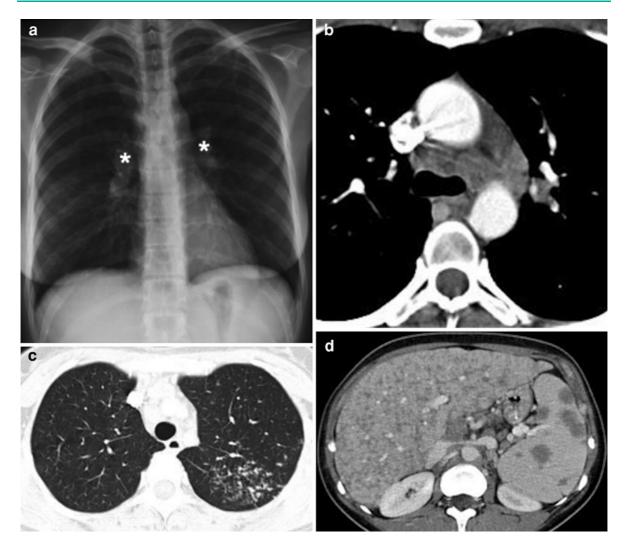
Sistemic sarcoidosis. (a) Chest X-ray. Enlarged ilar lymphnodes (*). MDCT of the thorax. Multiple hypoattenuating lymphnodes can be appreciated in the mediastinum (b) with small peribronchial nodules in the lung (c). In the abdomen
